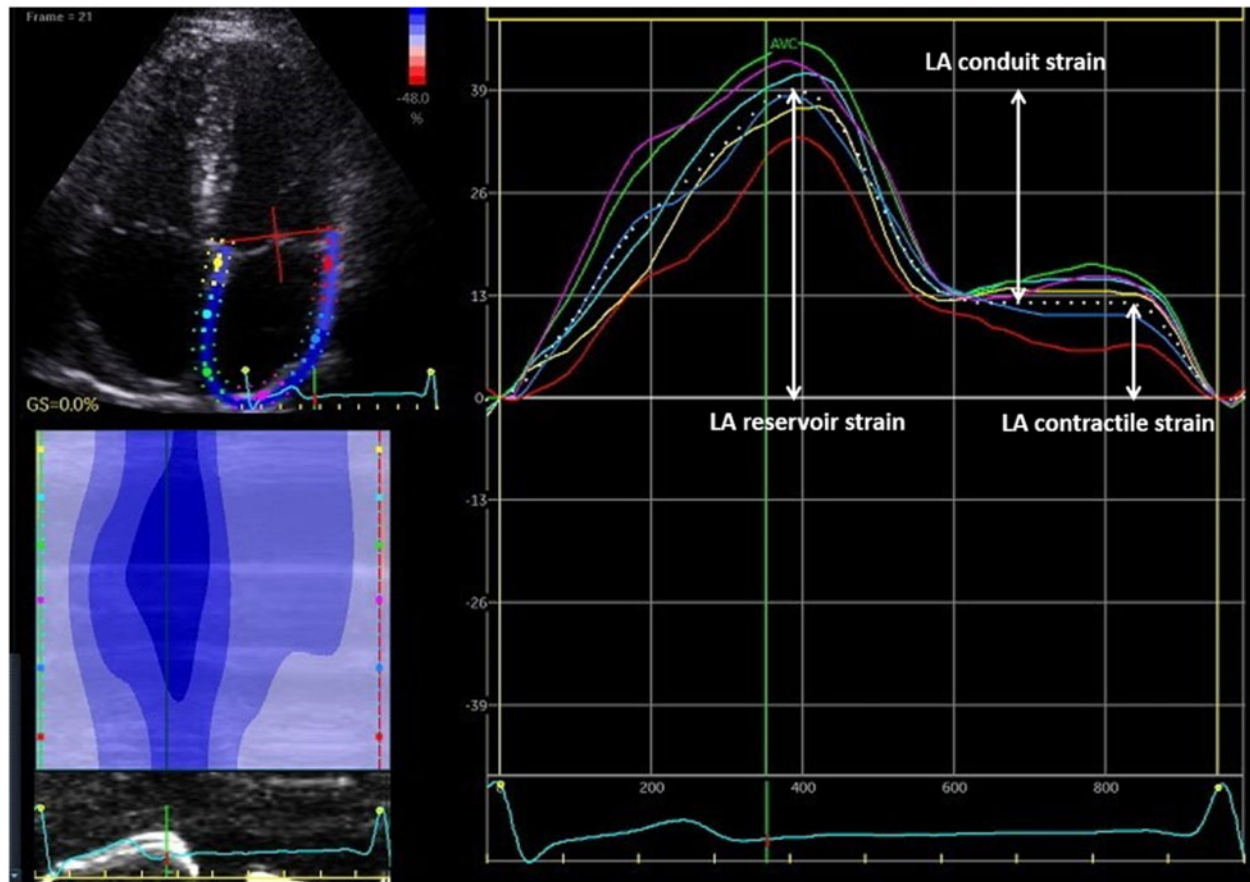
LA strain measurement (apical 4-chamber view) from six segments (different colours), with corresponding strain curves, and average strain curve (dotted line).
